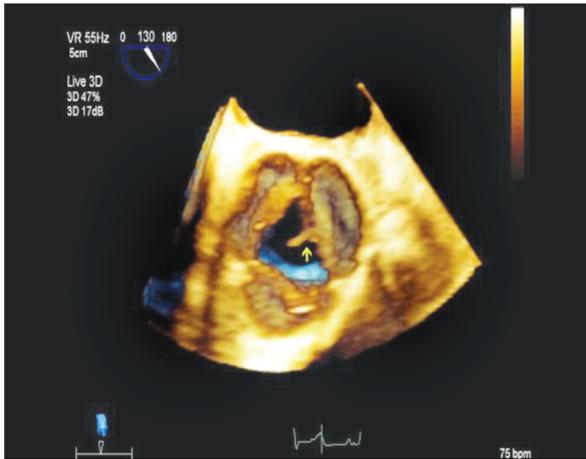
Live three-dimensional transesophageal mid-esophageal short axis view of the aortic valve. Arrow points to a linear mobile echodensity at the tip of the left coronary cusp consistent with a Lambl's excrescence.
